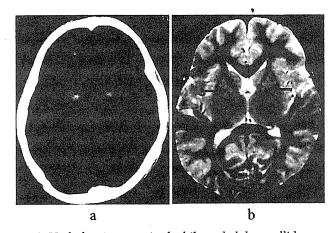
High density areas in the bilateral globus pallidus on brain CT (a), and the eye-of-the-tiger sign (arrows) on brain MRI.
